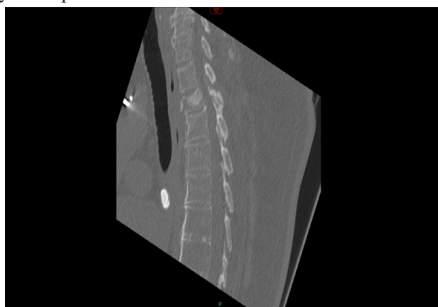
Initial CT scan showing T2 lesion
